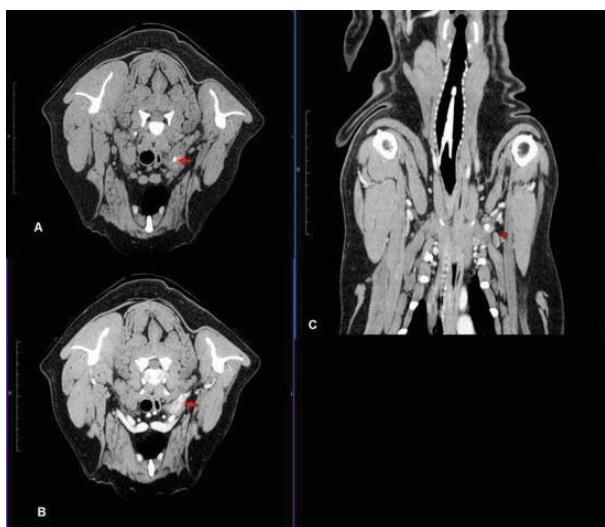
Computed tomographic of the axillary cervical region
